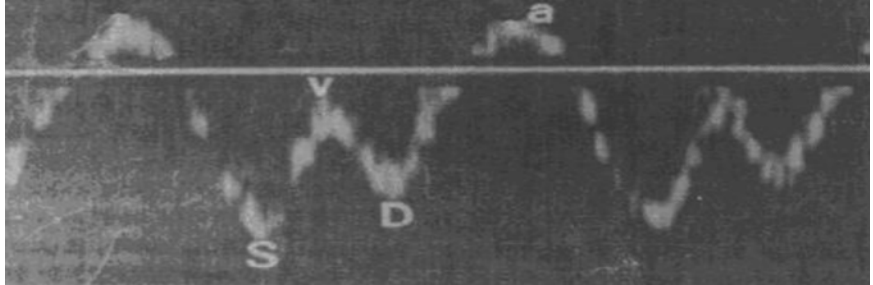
Doppler sonogram of hepatic vein in healthy adult by Abdu-Yousef.
